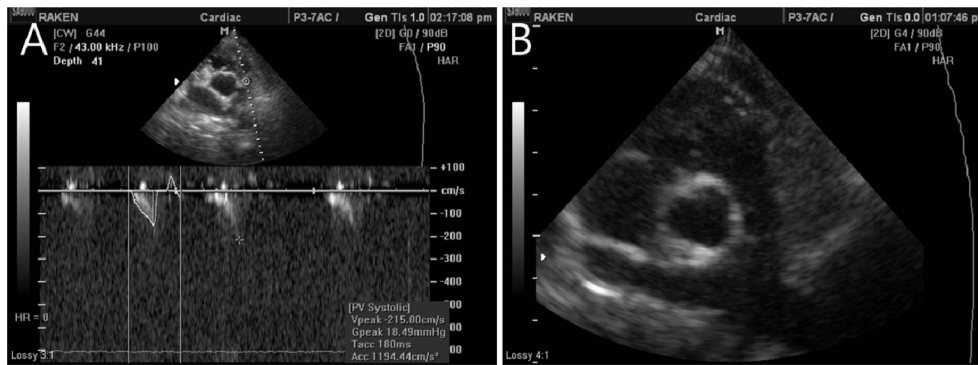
Echocardiography of this case. A: Continuous wave Doppler echocardiography taken one day after procedure revealed mild systolic jet flow with peak velocity of 2.1 m/s (PG = 18 mmHg). B: The 2-dimensional echocardiography in right parasternal short axis view taken one day after procedure revealed the RVOT was much wider and the fibrotic ring around pulmonic infundibulum was not clearly visible.
